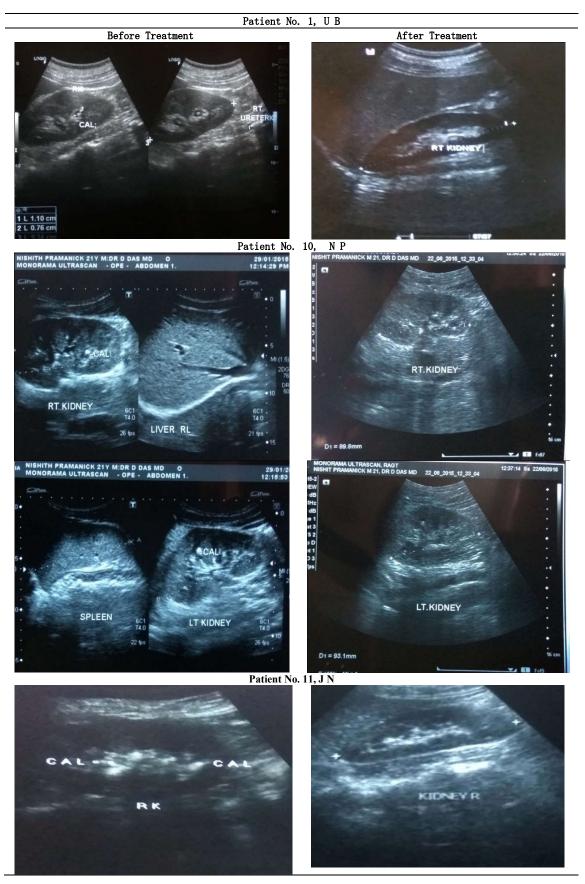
Ultra-sonographic images showing the removal of stone(s)
